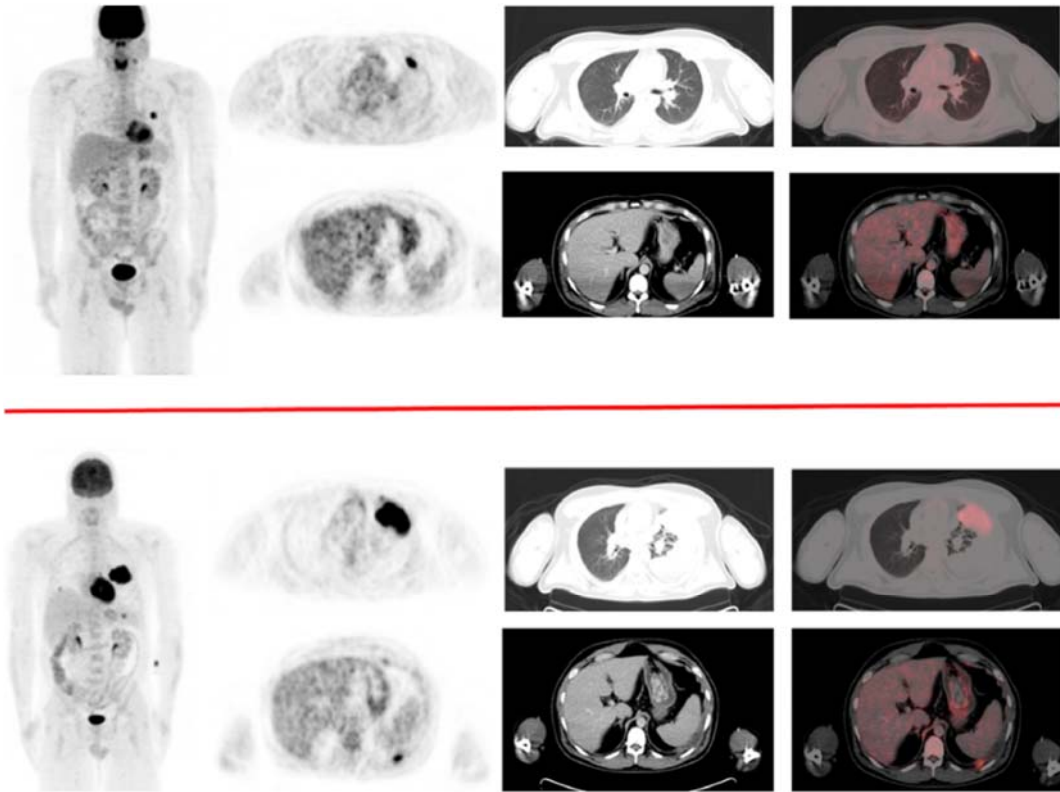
A 39-year-old male with a history of malignant melanoma resection from his right pinna in February 2012. Images from FDG PET/CT scan of October 2014 (top row) show a hypermetabolic pleural-based left lung nodule. No treatment was offered. A repeat FDG PET/CT scan of February 2015 (bottom row) shows progression of lung metastasis and a new focus of metastasis involving the diaphragm posterior to the spleen.
